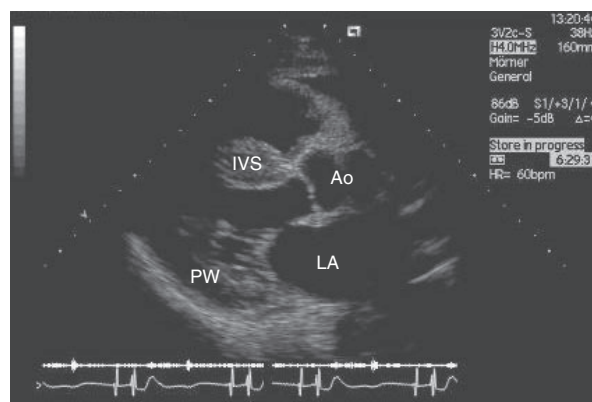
Echocardiogram from the 68-year-old male index patient. Parasternal long axis view, showing marked septal hypertrophy and also hypertrophy of the left ventricular posterior wall. IVS, interventricular septum; Ao, aorta; PW, posterior wall; LA, left atrium.
